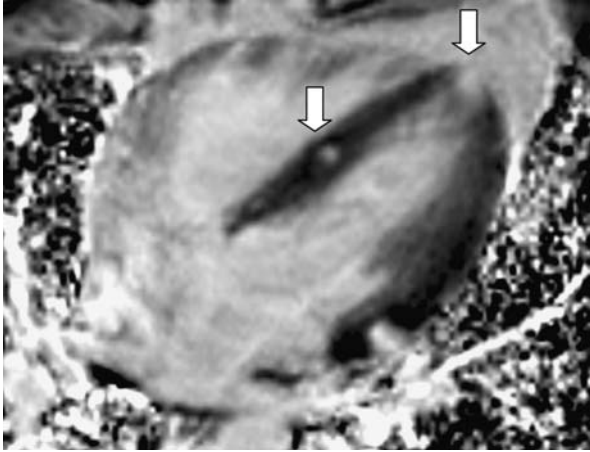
Delayed enhanced MR image from a 35-year-old man with sarcoidosis who presented with SCD. Focal enhancement of the interventricular septum, the apical left ventricle, and the lateral left ventricle are seen.
